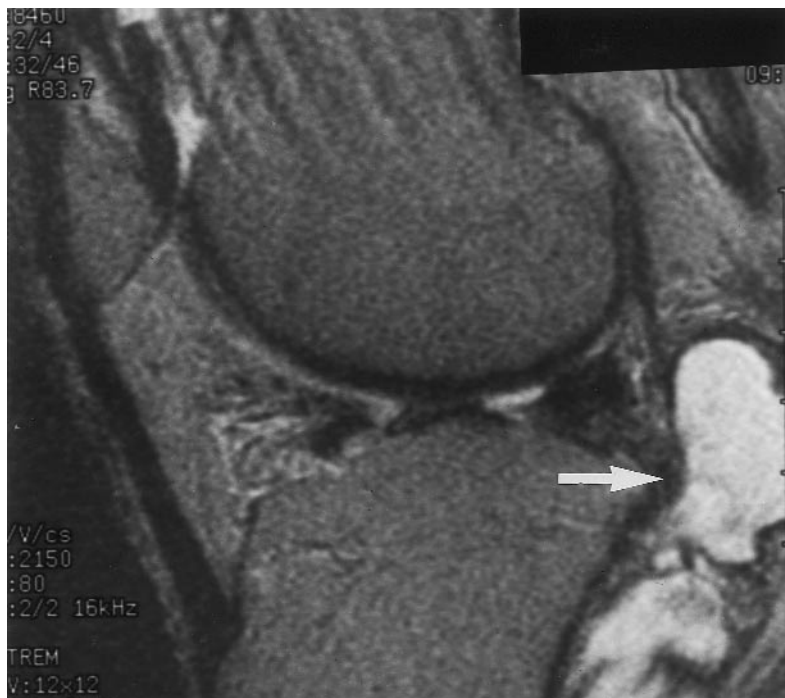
Sagittal T2 weighted MR images of popliteal cyst (grade 3, arrow).
